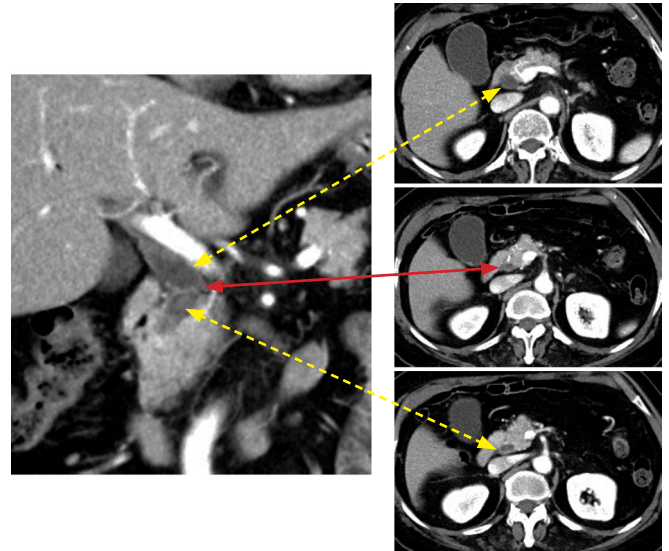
Follow-up computed tomography taken at 6 months after the treatment showing a thin doughnut-shaped web at the distal bile duct. Dotted arrows indicate the proximal and distal levels of the bile duct to the web. Solid arrow indicates the level of a web at the distal bile duct.
